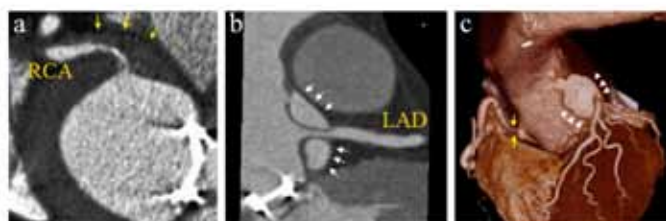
(A) Coronary computed tomography angiography showing the right coronary artery was embedded and oppressed by the intramural hematoma (yellow arrow), (B) On multi-planar reconstruction imaging, the left main trunk appeared to be mildly oppressed by the communicating false lumen (white arrow), (C) Volume rendering imaging showed that the proximal segment of the right coronary artery was oppressed (yellow arrow) and the left main trunk was embedded in the communicating false lumen (white arrowhead).
